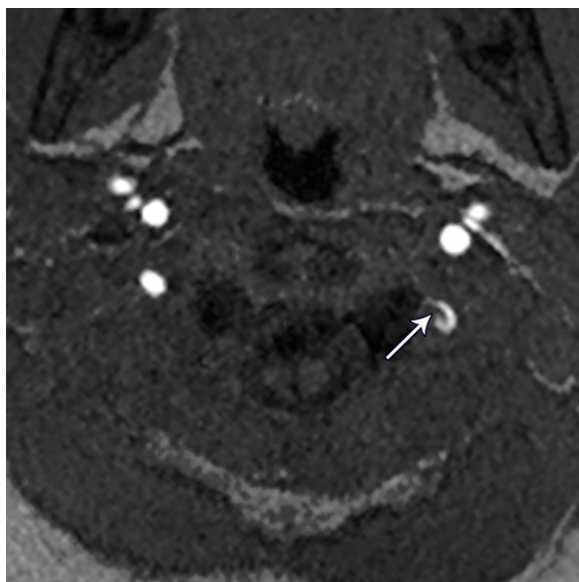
VAD with an intimal flap in a 14-month-old boy with vomiting, ataxia, and lethargy. Axial 3D TOF MR angiogram shows a linear filling defect (arrow) in the left vertebral artery, representing an intimal flap. Intimal flaps are uncommonly identified but are best seen on submillimeter source images from 3D TOF MR or CT angiograms.
